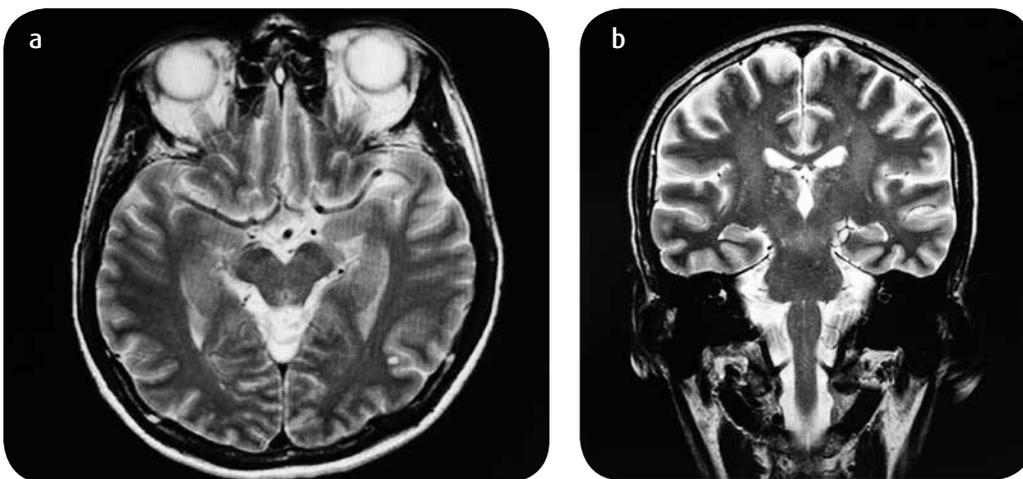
MRI sequences with T2 information: a) axial plane and b) coronal: High subcortical signal of micronodular appearance corresponding to the areas of enhancement in sequences with T1 information is identified.
